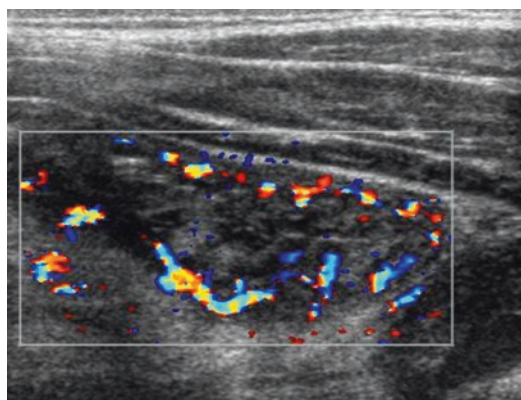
Twelve-year-old boy followed for CD. US Doppler demonstrates thickening and hyperemia of a jejunal loop associated with hyperechoic fat thickening (sclerolipomatosis)
